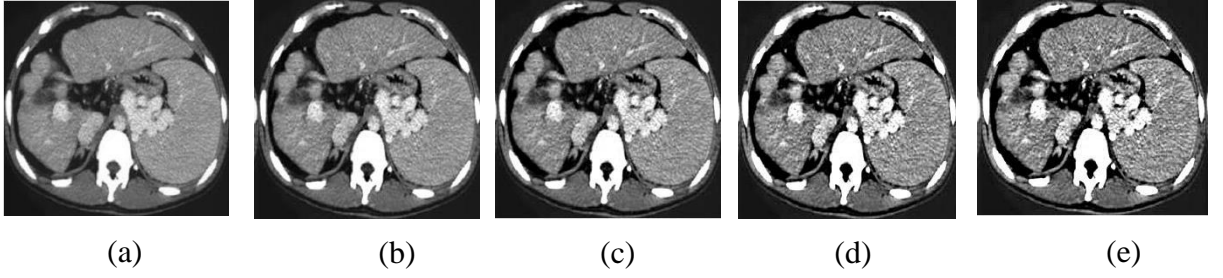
The adaptive top hat transform results with different β s (a) Original test CT image. (b) $\beta = 0.2$. (c) $\beta = 0.4$. (d) $\beta = 0.8$. (e) 1.0
